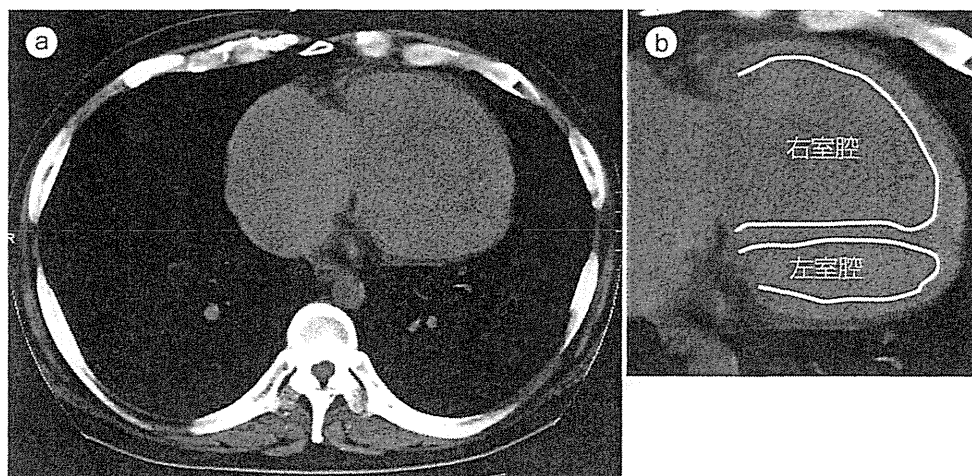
PVOD 症例の単純 CT 像 (縦隔条件)
